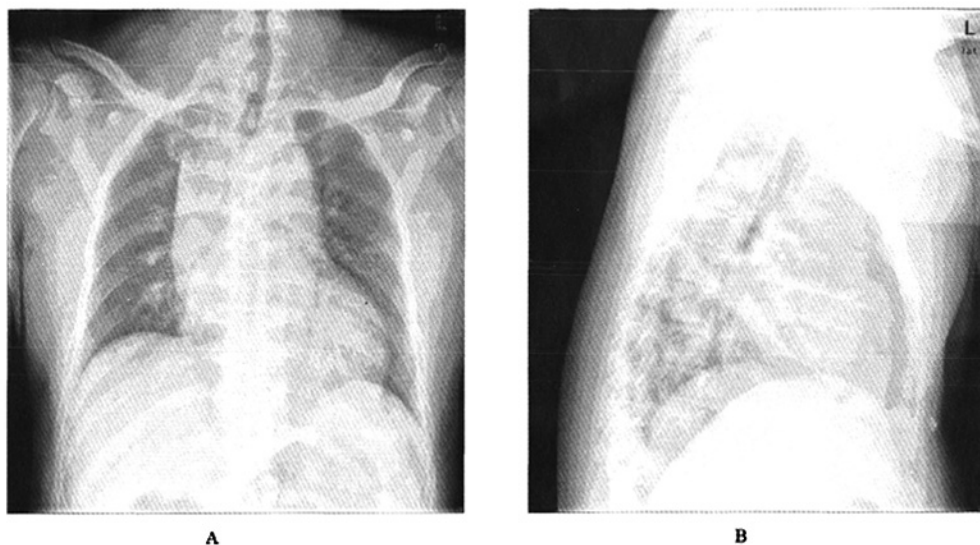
Chest X-ray examination
